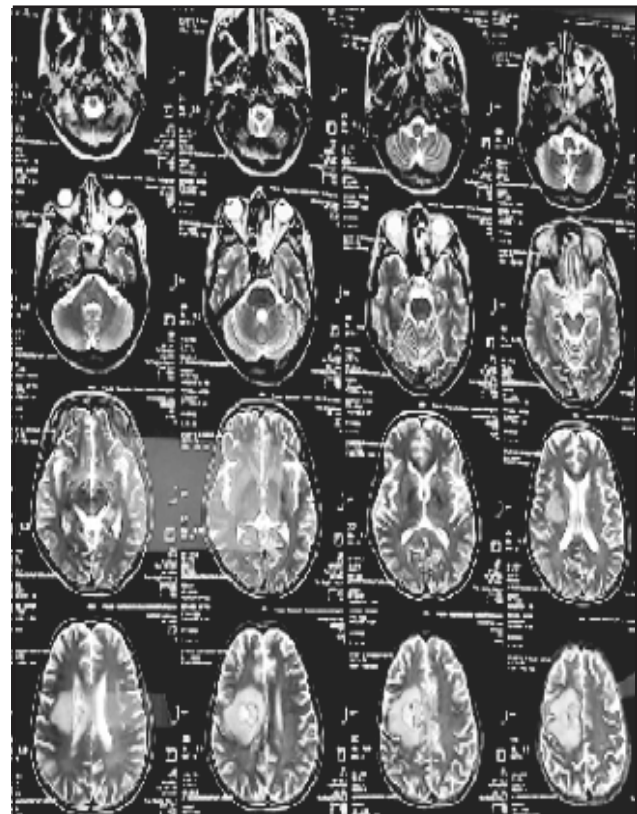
CT of brain of patient
